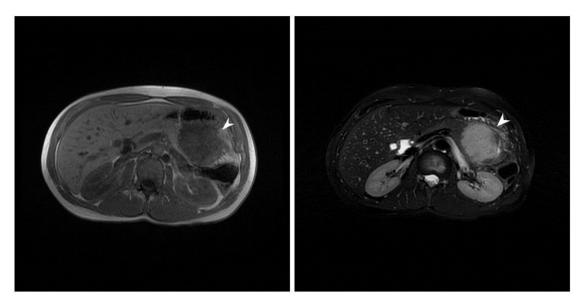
Axial T1-weighted (a) and fat-suppressed T2-weighted (b) magnetic resonance images.
